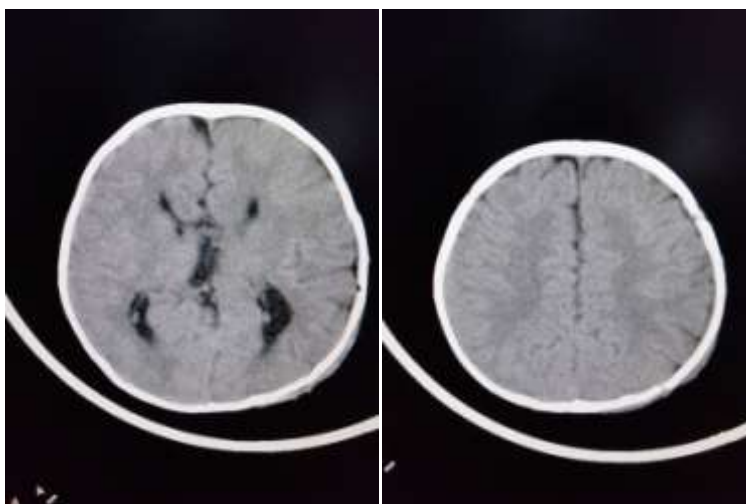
Postoperative CT with complete evacuation of EDH with no midline shift with normal left lateral ventricle.
